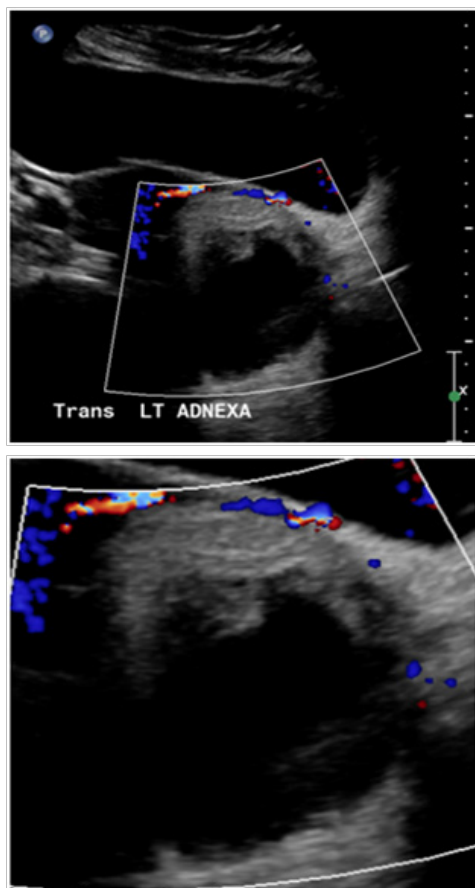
Pelvic ultrasound showing Complex left adnexal mass measuring approximately 8.2 × 8.8 × 7.9 cm as well as small amount of free fluid.
